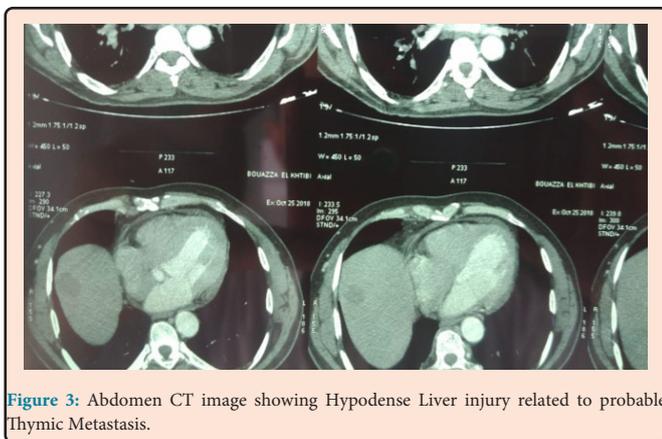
Abdomen CT image showing Hypodense Liver injury related to probable Thymic Metastasis.
